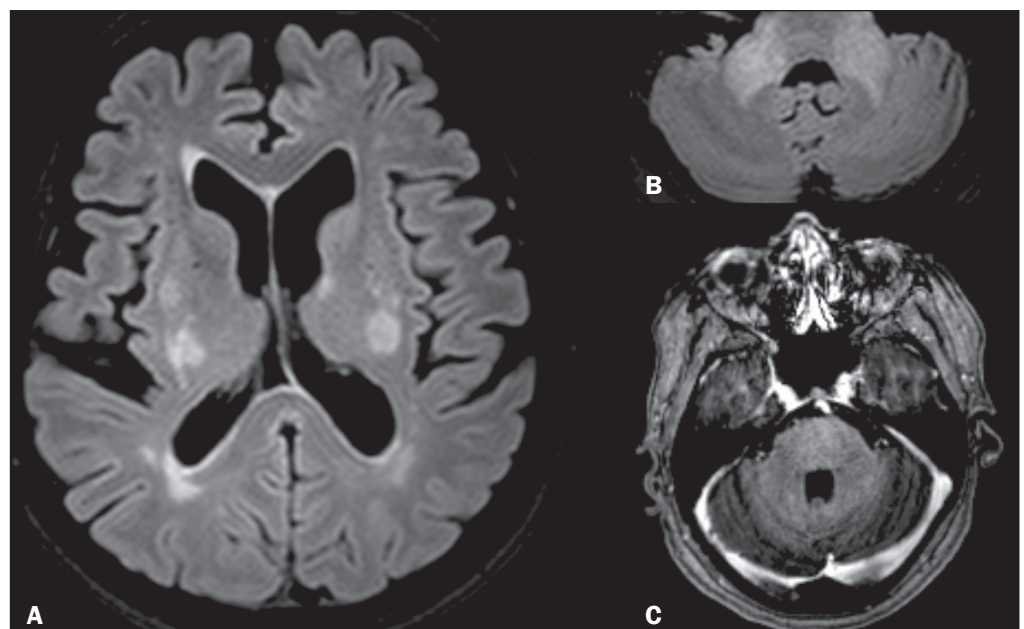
ADEM. A: Axial FLAIR sequence demonstrating supratentorial lesions involving the white and grey matter (basal ganglia and left thalamus). B: Axial FLAIR sequence depicting bilateral hyperintense MCP lesions. C: Contrast-enhanced T1WI showing no enhancement in the MCP lesions.
